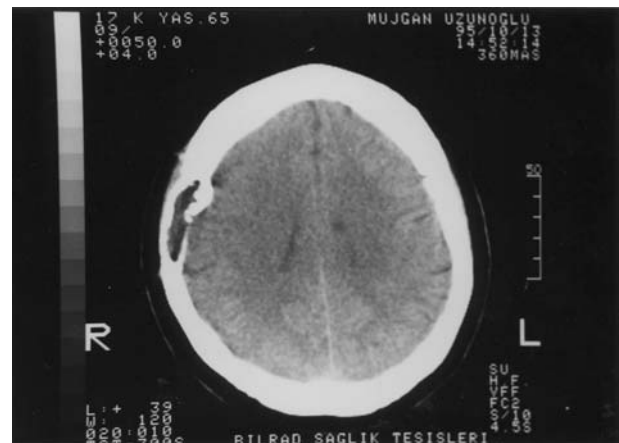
CT scan showing an intradiploic hypodense lesion; with thinned internal and external tables
